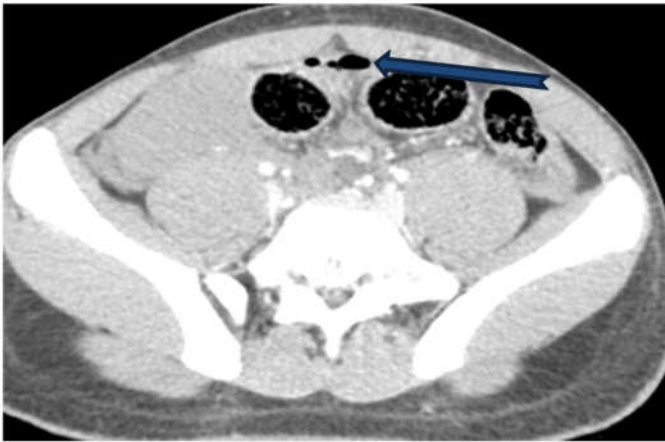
Plain CT showing pneumoperitoneum (blue arrow pointing gas)
